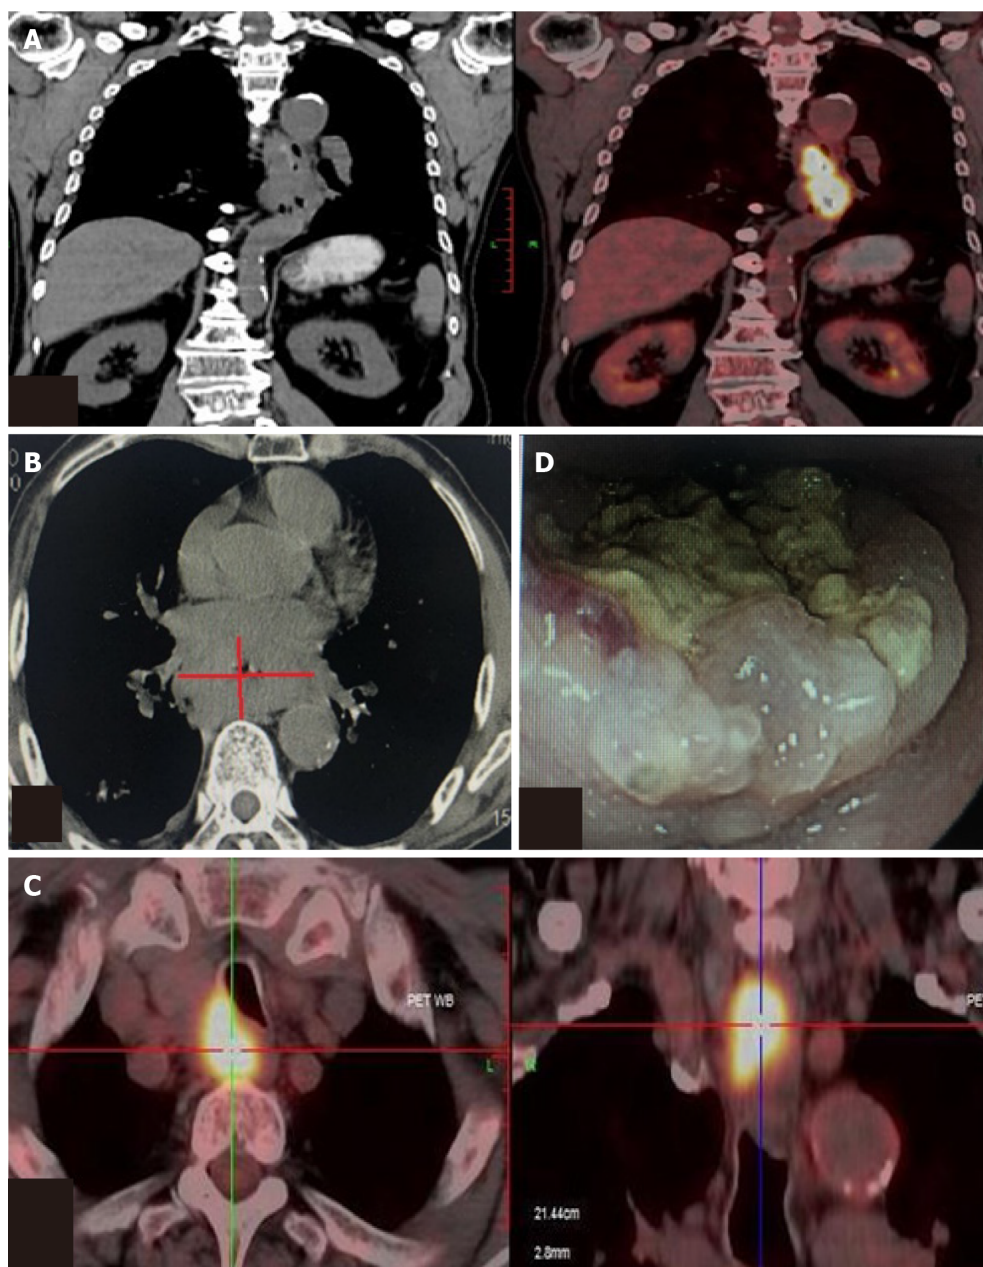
Positron emission tomography-computed tomography, computed tomography and endoscopy demonstrated a tumor sited in the middle and lower esophagus and multiple lymph nodes metastasis. A: Positron emission tomography-computed tomography showed esophageal carcinoma; B: Computed tomography showed esophageal carcinoma; C: Multiple lymph nodes metastasis; D: Endoscopy outcome.
